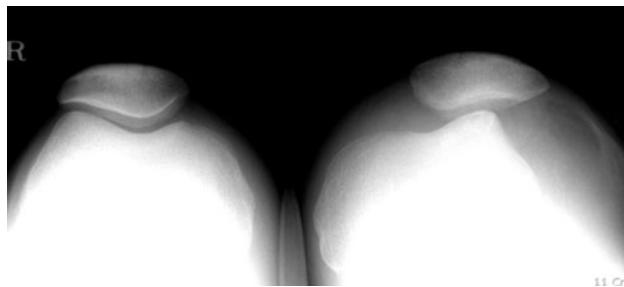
Skyline radiograph of the knee joint showed large soft tissue density on the anterolateral aspect of left knee joint with patellar dislocation from the trochlear groove
